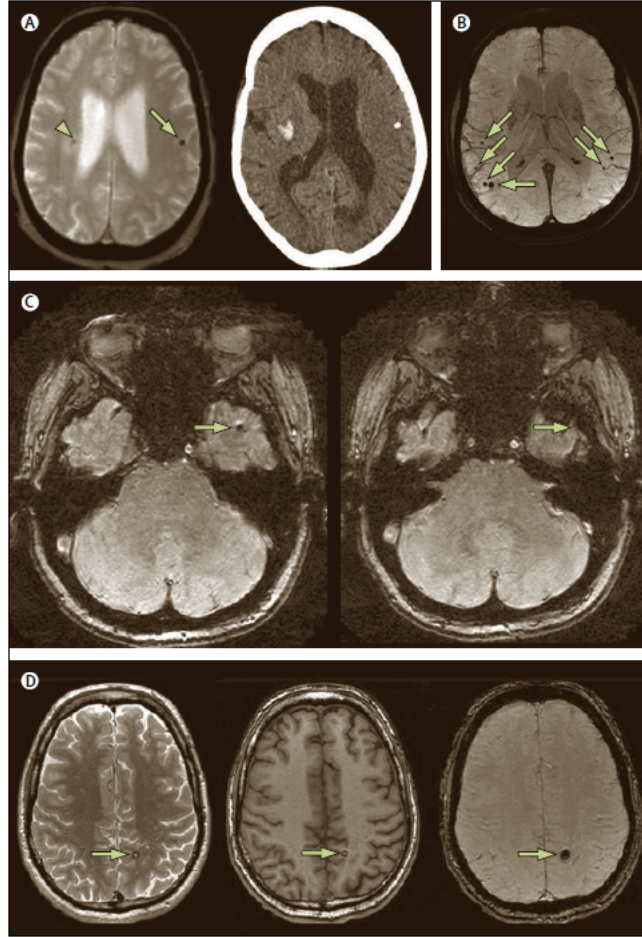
(A) calcification in T2*-weighted MRI (left panel; arrow) mimics CMB. The CT scan shows the calcification as a high density area (right panel). (B) Axial T2*-weighted MRI scan shows CMBs (indicated by arrows) close to blood vessels. The vessels can be distinguished from CMBs by their tubular shape. (C) Partial volume artifact in T2*-weighted MRI scan as a CMB mimic. T*-weighted MRI (left panel) shows a circular region of signal loss (arrow) which can be mistaken as a CMB. left sphenoid bone (right panel) which shows the adjacent sphenoid bone (arrow). (D) Axial proton density-weighted (left panel), T1-weighted (middle panel), and T2*-weighted (right panel) MRI scans indicate a cavernous malformation (arrows) as a CMB mimic. The proton density or T2-weighted sequences distinguish these lesions from CMBs [12].
